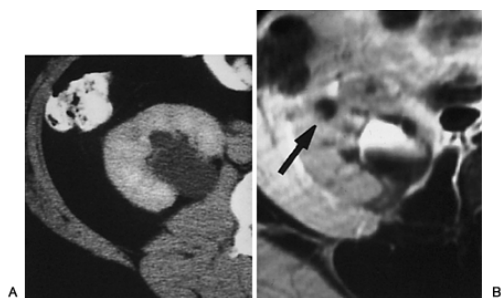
5. The value of magnetic resonance imaging (MRI) in indeterminate renal masses. A: Contrast-enhanced computed tomography (CT) scan shows an inhomogeneous renal parenchyma but no definite focal masses. B: Postcontrast T₁-weighted image demonstrates a cystic mass in the right kidney with a small mural nodule (arrow), as well as several additional smaller lesions in the parenchyma. The patient had a ureteropelvic junction stenosis, accounting for the dilated renal pelvis. The fluid level in the renal pelvis on the MRI is due to the more concentrated gadolinium layering below the less concentrated (bright), more dilute urine.
